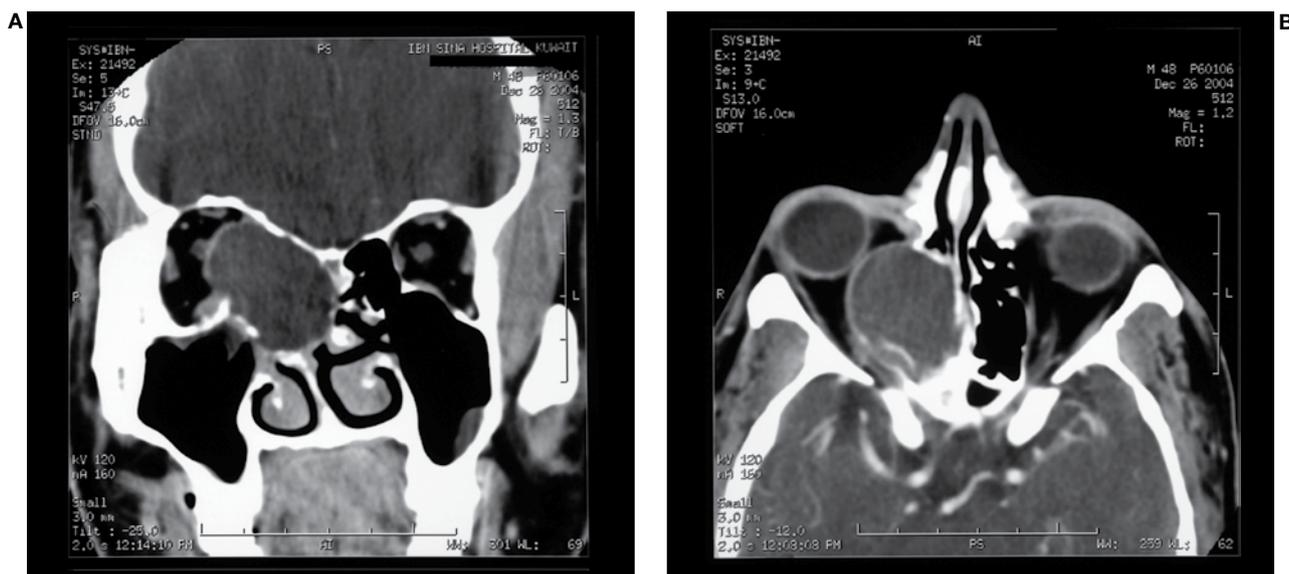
Patient 3. A: Coronal CT scan shows the right-sided mucopyocele in the right ethmoid labyrinth. B: This axial CT shows the mucopyocele displacing the orbit.
